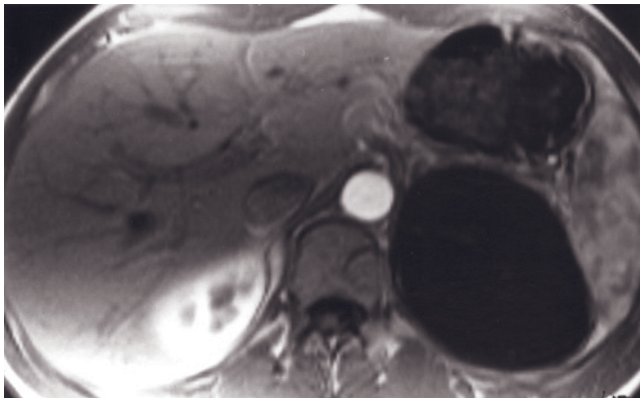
(Continued) (arrow, *e*), which are well shown on the breathing-independent T2-weighted image (*d*) and show faint enhancement on the interstitial-phase gadolinium-enhanced fat-suppressed image (arrow, *g*). T2-weighted HASTE (*b*) and coronal T2-weighted HASTE (*i*) images in a third patient. A pseudocyst in the left adrenal appears on the T2 images (*b*, *i*) with hypointense septations. Coronal T1-weighted GE (*j*), coronal T2-weighted HASTE (*k*), T1-weighted GE (*l*), T1-weighted out-of-phase GE (*m*), T2-weighted HASTE (*n*), immediate postgadolinium GE (*o*), 90-s postgadolinium fat-suppressed GE (*p*), and sagittal postgadolinium GE (*q*) images in a fourth patient. A large left adrenal cyst displaces the kidney inferiorly and the spleen anterior and laterally (*j*, *k*, *q*).
